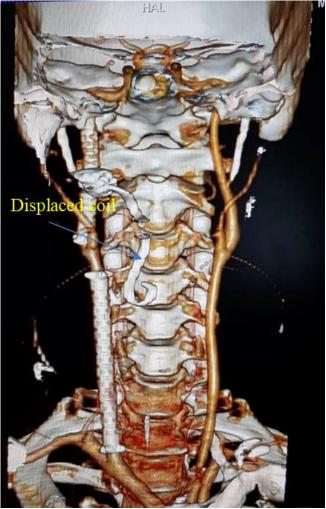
CT angiography images showing stent graft in position, dislodged coil and no new aneurysm as a cause of bleeding.
